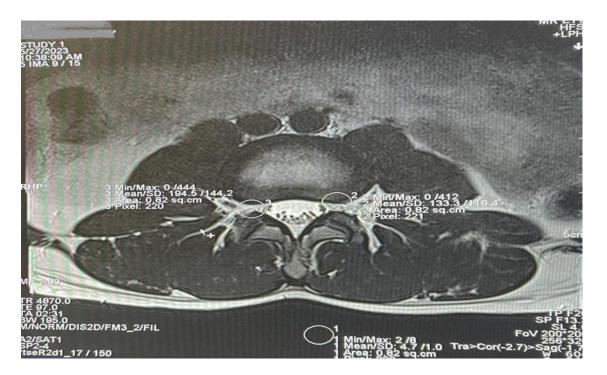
The ROI Statistics on the MR image for a specific area of the lumbar spine to calculate CNR
